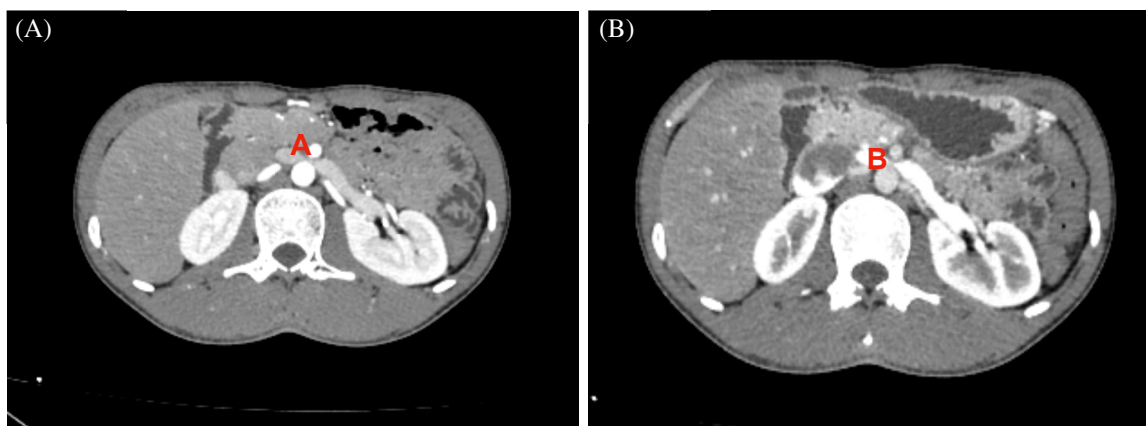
Arterial (A) and venous (B) phase CT images of Case 3
